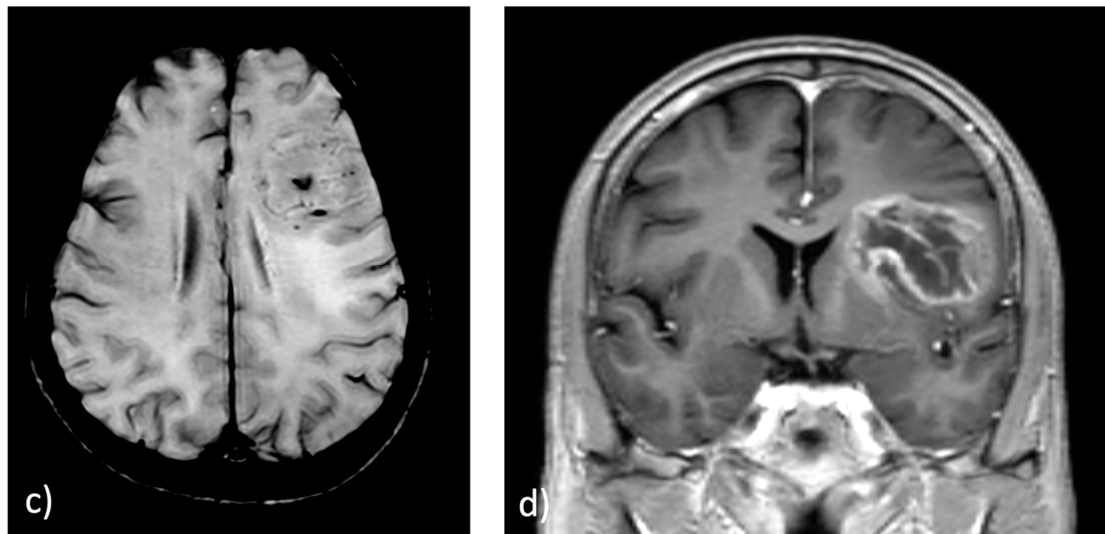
MRI brain—conventional sequences in a 45-year-old female who presents with slurring of speech and left-sided weakness. (a) Axial T2WI shows an isointense to hyperintense signal intensity lesion involving the left fronto-insular region, showing (b) patchy diffusion restriction in axial DWI and (c) Foci of Intratumor Susceptibility (ITSS) in SWI. (d) Coronal post-contrast T1 image shows heterogenous post-contrast enhancement with areas of central necrosis. Imaging features suggestive of high-grade diffuse glioma.
